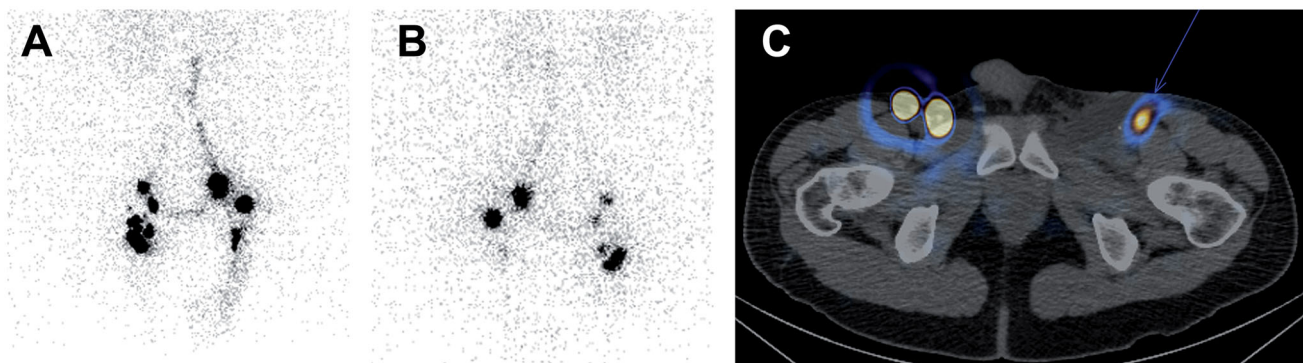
Preoperative (a,b) lymphoscintigraphic images and SPECT/CT (c) of patient 2 showing reduced nodes captation at the left groin, with lymphatic leak associated to inguinal seroma.
